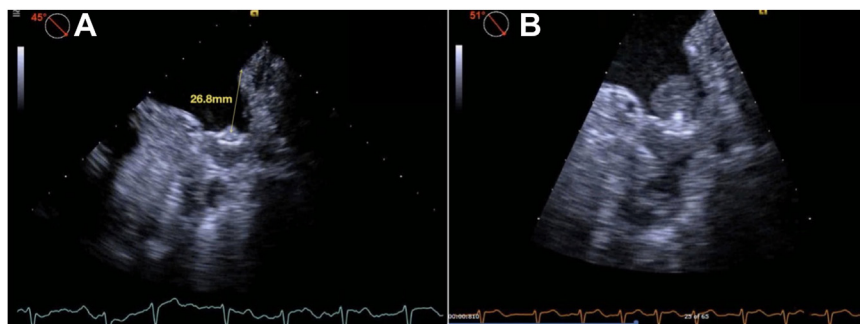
Transesophageal echocardiographic imaging in a patient with a Watchman FLX (Boston Scientific, Marlborough, MA) device implant. (A) Implant depth of 26.8 mm, measured as the distance from the limbus of the oblique ridge to the centre of the left atrial aspect of the Watchman device in the 45° view on transesophageal echocardiogram performed at the time of implantation. Such deep implants, especially with depth measurements > 2 cm, should not be accepted as a satisfactory result, and the device should be repositioned more proximally in the left atrial appendage ostium. (B) Device-related thrombus, as seen in the 45° view on transesophageal echocardiogram performed at 14 months postimplant. The patient was on single-antiplatelet therapy at the time of diagnosis.
